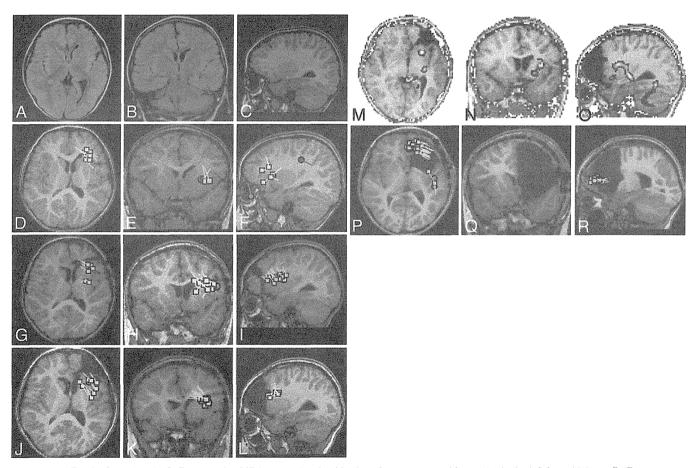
Case 4. A–C: Preoperative MR images showing blurring of gray matter—white matter in the left frontal lobe. D–F: Preoperative magnetoencephalograms showing a cluster of spike dipoles in the deep white matter of the left frontal lobe. Dipole sources with a goodness-of-fit better than 90% (yellow squares) and 80% (green circles) were accepted and overlaid on the MRI results. A somatosensory evoked magnetic field was obtained on stimulation of the right median nerve (red circle). G–I: Magnetoencephalograms obtained after the first frontal lobe disconnection surgery, revealing a cluster of spike dipoles in the deep white matter of the residual frontal lobe. J–L: Magnetoencephalograms obtained after a second partial frontal lobectomy, revealing a cluster of spike dipoles in the head of the caudate nucleus and the deep white matter of the residual frontal lobe. M–O: Subtraction ictal SPECT coregistered with structural MRI (SISCOM) revealing hyperperfusion of the nucleus accumbens and the deep white matter of the left frontal lobe. P–R: Magnetoencephalograms obtained after the third surgery, a partial resection of the anterior striatum and residual frontal lobe, showing a cluster of spike dipoles mostly in the disconnected frontal lobe and slightly in the margin of the residual brain tissue.
